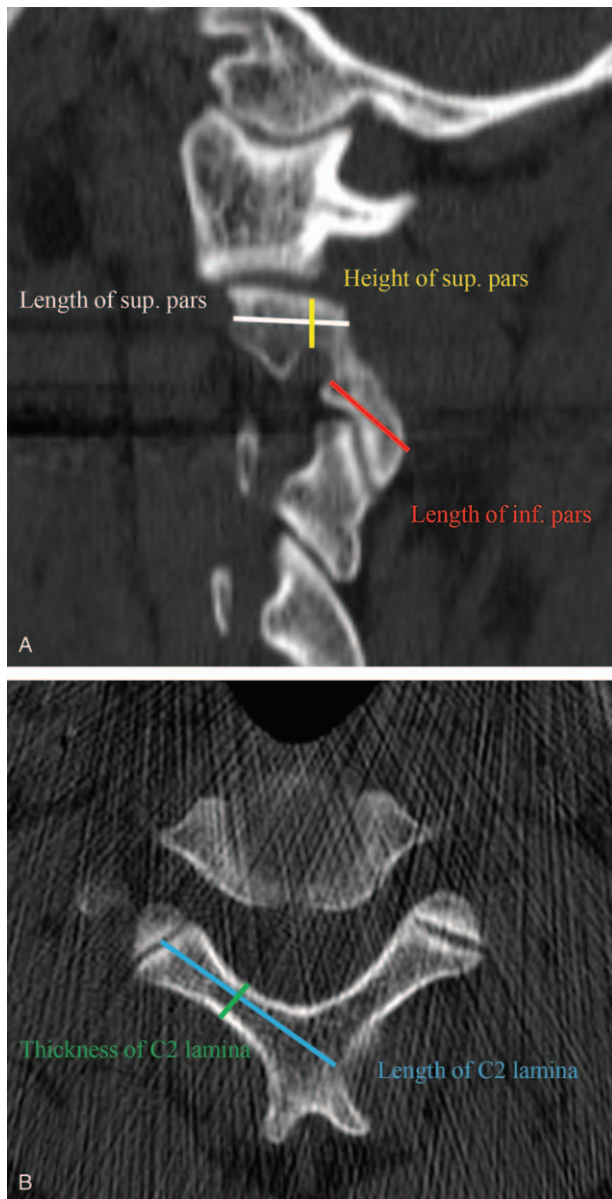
The five C2 morphometric variables on sagittal and axial CT images. (A) Length (white) and height (yellow) of superior pars and length (red) of inferior pars. (B) Length (light blue) and thickness (green) of C2 lamina.
